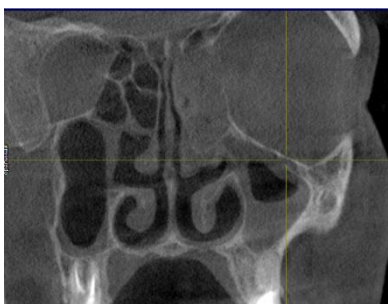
Patient D., 31 years old. 3D radiography of the paranasal sinuses. Identification of subtotal and total areas of blackouts in the left maxillary sinus and ethmoid cells
